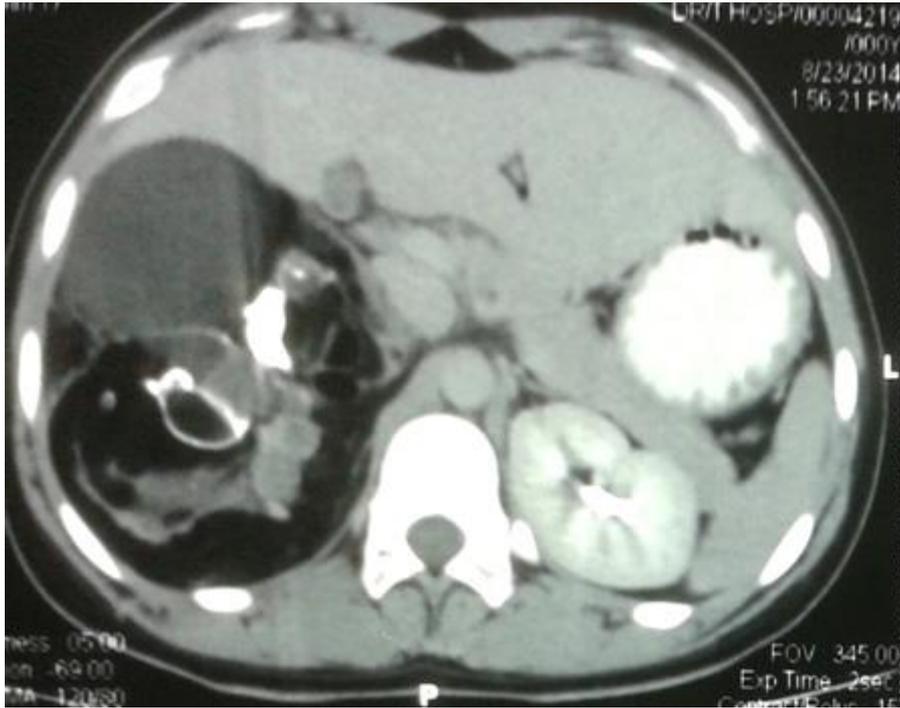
Abdominal contrast-enhanced computed tomography (CT) scan. Cross-sectional view: showing a large lesion in the region of right adrenal gland measuring 12 × 11 × 09 cm and demonstrating multiple cystic spaces with thin septations as well as multiple areas of fatty collections and coarse calcifications
